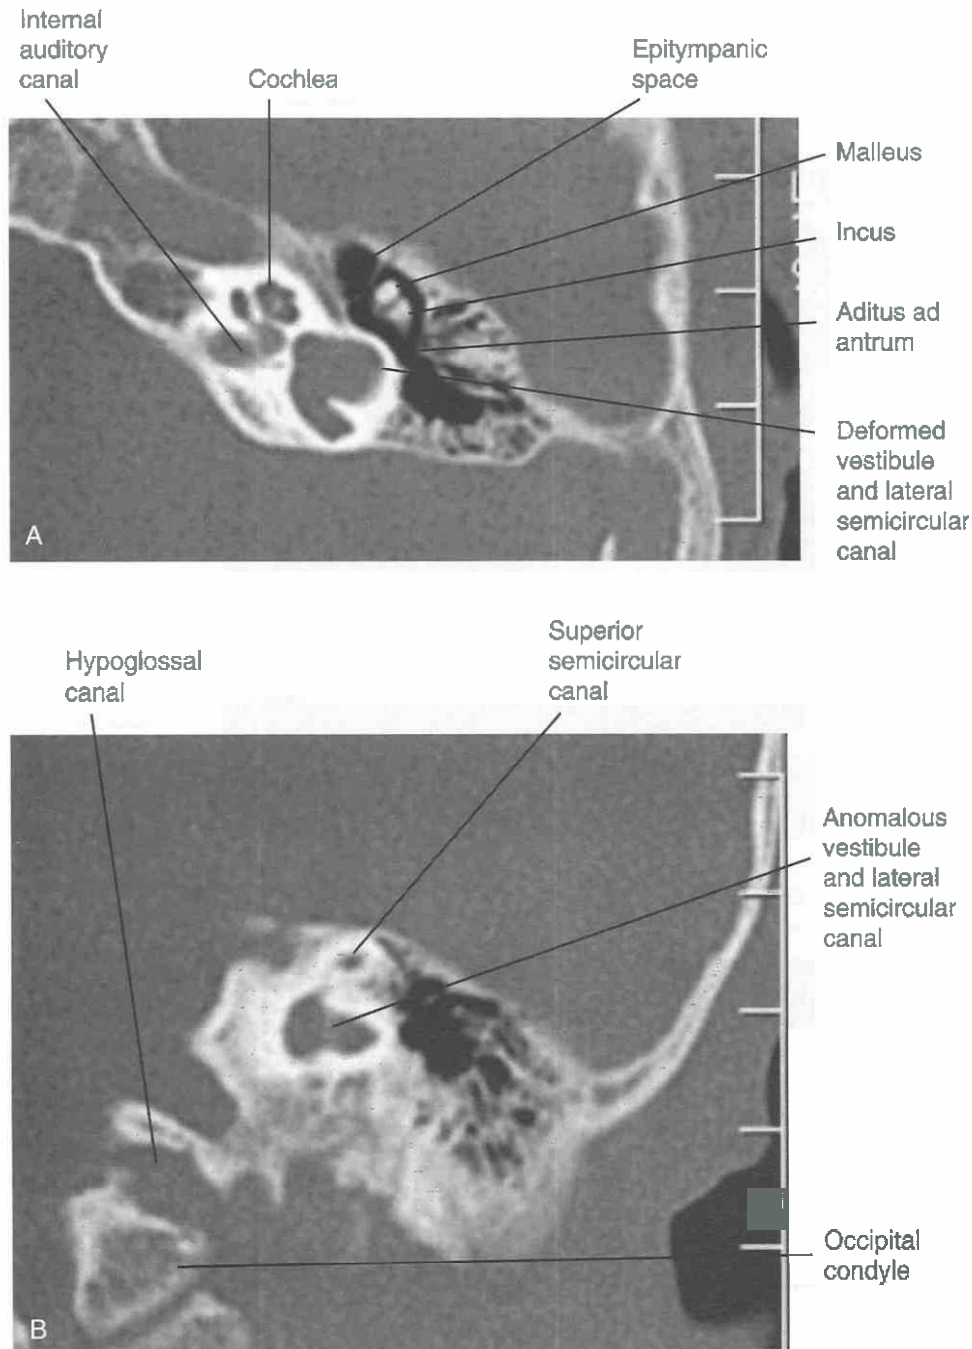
Vestibular anomaly. *A*, Axial CT image at the level of the vestibule, epitympanic space, and cochlea. The ossicles and middle ear are normal. The cochlea is dysplastic. The vestibule is deformed with a bulbous configuration. The vestibule fuses with the lateral semicircular canal. The posterior semicircular canal is also enlarged. It is important to exclude an abnormal fistulous connection between an otic capsule abnormality and the middle ear. *B*, Coronal CT slice sectioned through the anomalous bulbous vestibule. The hypoglossal canal, superior semicircular canal, and occipital condyle are normal.
